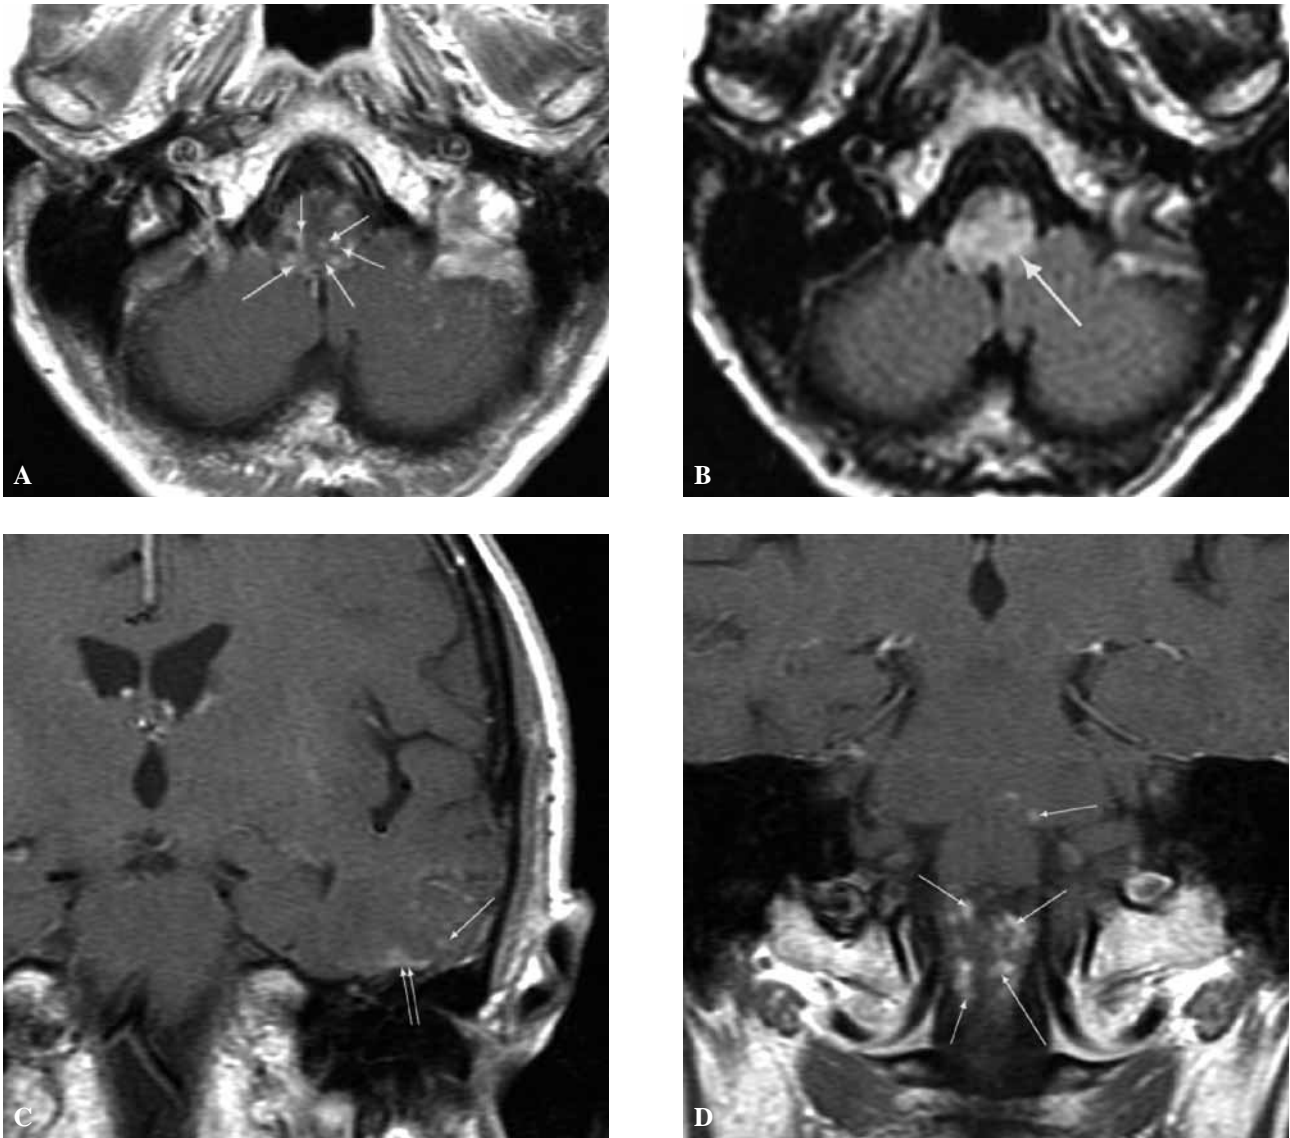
Initial magnetic resonance (MR) images at admission. A : Contrast-enhanced transverse T1-weighted image at the level of the medulla oblongata showing multiple thin enhanced foci within medullar parenchyma (arrows). Medulla appears slightly swollen ; B : FLAIR image at the same slice location as previous image showing abnormal hypersignal intensity within involved parenchyma which reflects oedematous changes (arrow) ; C : Coronal post-contrast T1-weighted magnified view showing abnormally enhanced foci within left temporal meninges (paired arrows) and parenchyma (single arrow) ; D : Coronal post-contrast T1-weighted view showing the constellation of thin enhanced parenchymal foci within medulla. A few similar foci are seen within the pons (arrows).
